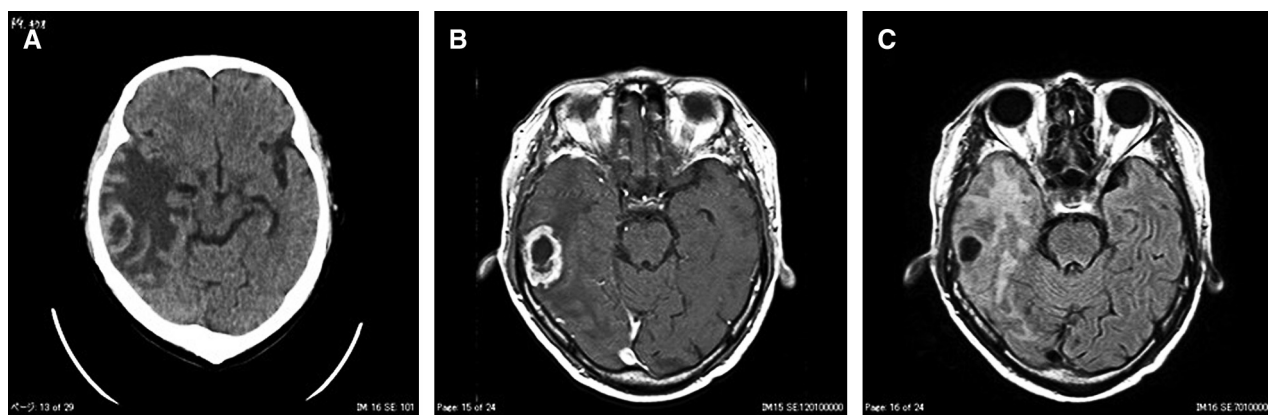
Preoperative images. (A) Preoperative CT. (B, C) Preoperative MRI showed a right temporal lobe tumor with peripheral edema. The periphery of the tumor was enhanced by contrast medium. MRI: magnetic resonance imaging.
